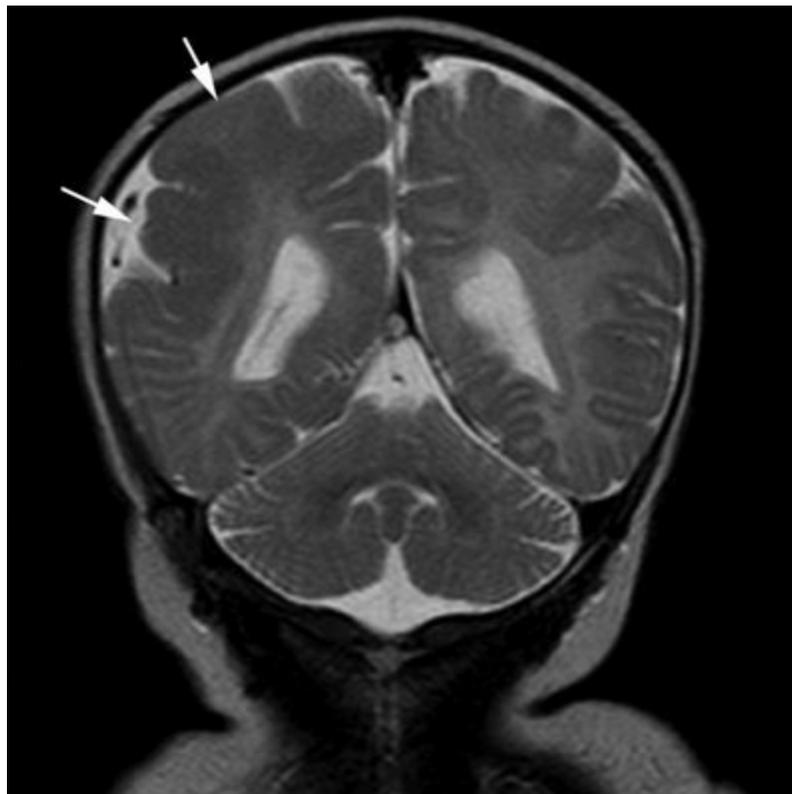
Polymicrogyria. Coronal T2-weighted image from MRI without gadolinium in a newborn with motor seizures shows generalized thickening of the cortex of the right parietal lobe characterized by multiple small gyri (arrows). Polymicrogyria are usually epileptogenic lesions, sporadic or familial in occurrence, and various brain MRI patterns have been recognized that help in making an accurate diagnosis.
